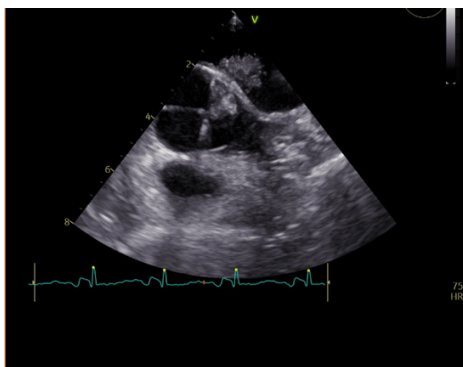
Echocardiogram showing intra atrial mass.
